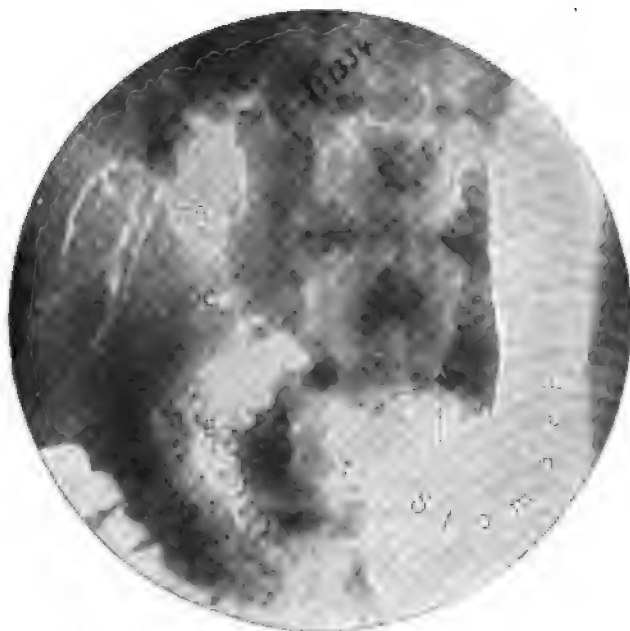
Roentgenogram: A, Carcinoma, pyloric end of stomach; B, duodenum; G. B., barium in gall-bladder; C, barium in hepatic ducts.
